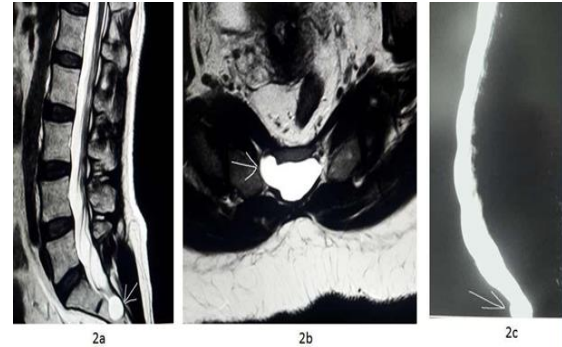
Case #2: MRI Lumbosacral spine of 63-years old male anaesthetist with low backache and urinary bladder disturbances. (a) T2W Sagittal section shows a well defined hyperintense lesion on the dorsal aspect of S2 vertebra (white arrow). (b) T2W axial section shows the same lesion on right side at the same level with some bony erosion (white arrow). (c) MR myelography shows a well defined rounded prominence at the caudal end of the spinal cord (white arrow).
